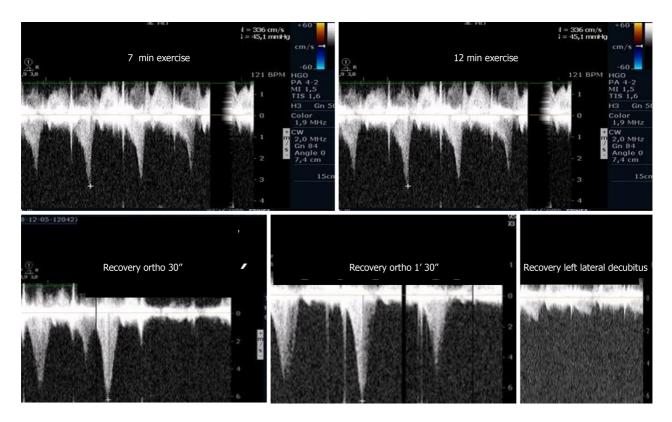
Intraventricular gradient increased during the last portion of the exercise test and after exercise in the orthostatic position. Obstruction suddenly disappeared after placing the athlete in decubitus. Citation: Cotrim C, João I, Fazendas P, Almeida AR, Lopes L, Stuart B, Cruz I, Caldeira D, Loureiro MJ, Morgado G, Pereira H. Clinical applications of exercise stress echocardiography in the treadmill with upright evaluation during and after exercise. Cardiovasc Ultrasound 2013; 11: 26. [PMID: 23875614 DOI: 10.1186/1476-7120-11-26] Copyright © The Author (s) 2013. Published by BMC part of Springer Nature.
